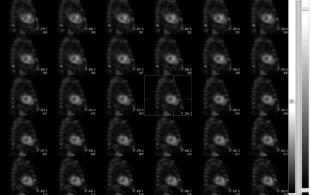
Technetium 99m pyrophosphate scintigraphy of the patient. Top image showing the heart to contralateral lung (H/CL) ratio measuring 1.78, which is strongly suggestive of cardiac amyloidosis. Bottom image confirming radiotracer uptake in the myocardium.
